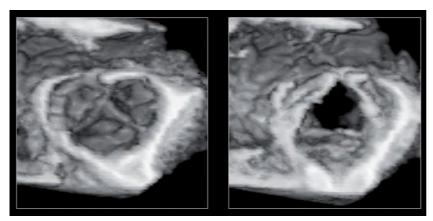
Three dimensional transoesophageal echocardiographic image at the level of the tricuspid aortic valve, displayed from the perspective of the aortic root (looking into the left ventricular cavity) in a patient with a widely patent trileaflet aortic valve (left panel shows diastole, right panel shows systole)
